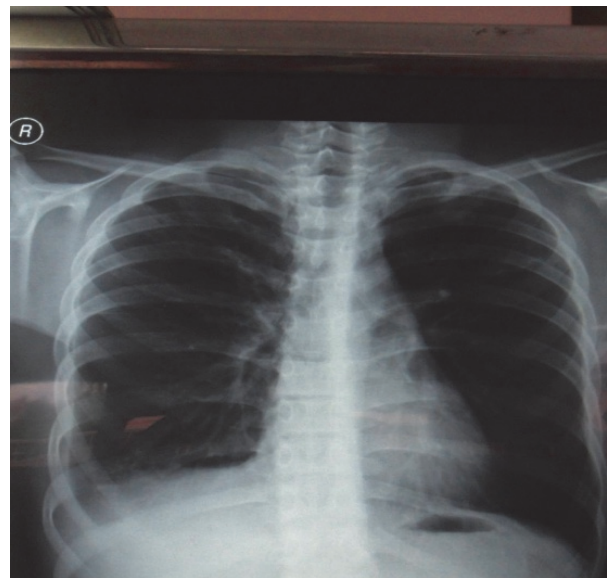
Chest radiography (X-ray) after two months of antituberculosis treatment.
